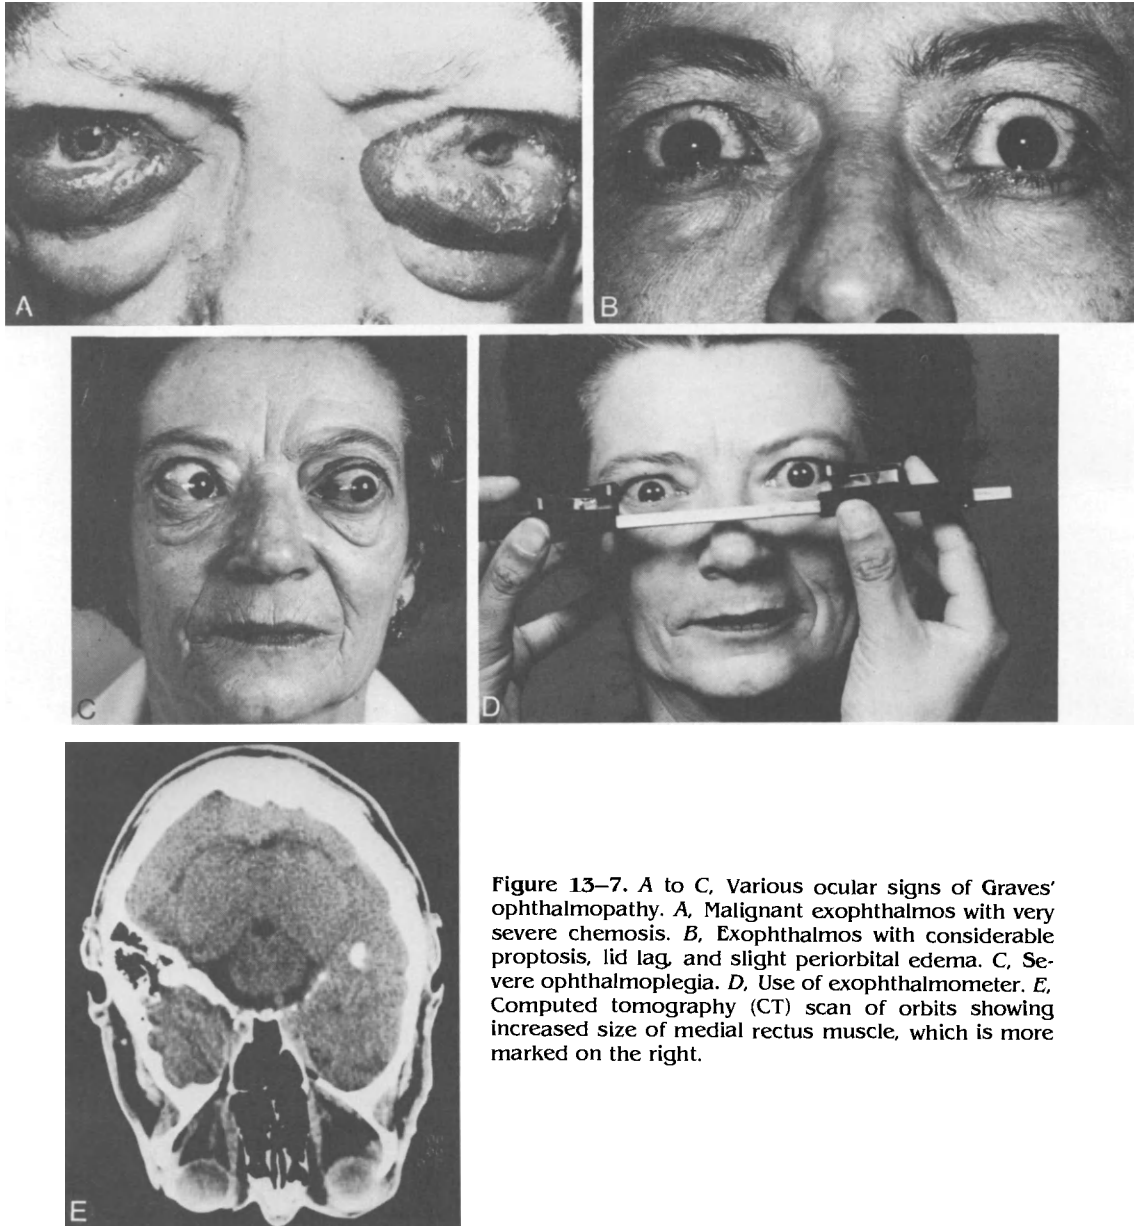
A to C, Various ocular signs of Graves' ophthalmopathy. A, Malignant exophthalmos with very severe chemosis. B, Exophthalmos with considerable proptosis, lid lag, and slight periorbital edema. C, Severe ophthalmoplegia. D, Use of exophthalmometer. E, Computed tomography (CT) scan of orbits showing increased size of medial rectus muscle, which is more marked on the right.
